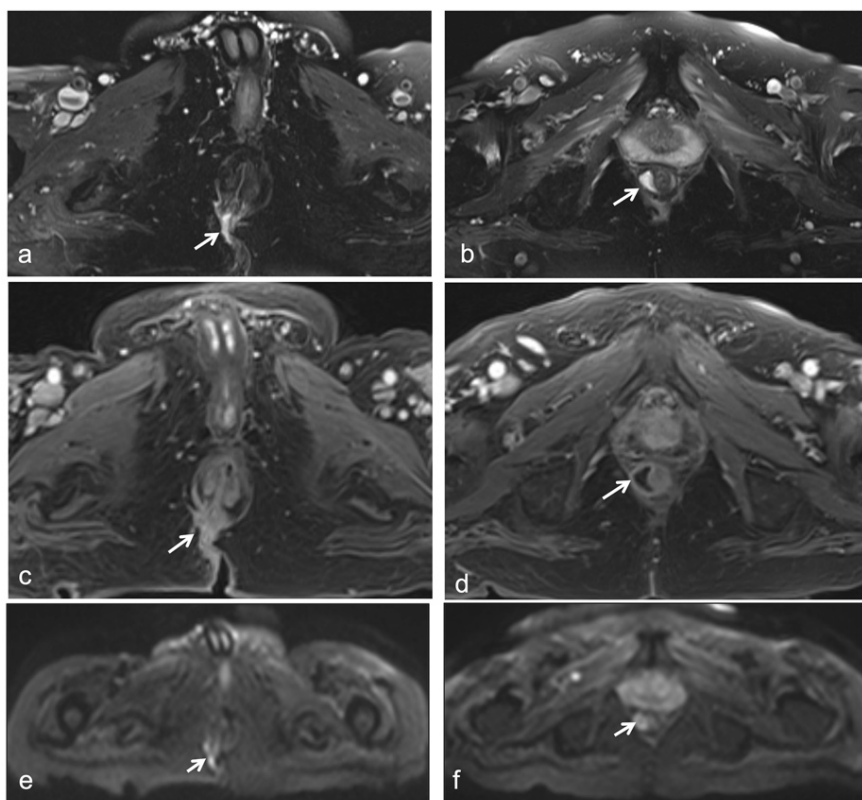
1,5T perianal MR imaging with i.v. contrast media injection of the same patient. a and b; axial T2W FS images a. hyperintense transphincteric fistula tract at 6 o'clock position (arrow), b. accompanying perianal abscess in the intersphincteric space (arrow). c and d; axial postcontrast T1W FS images c. hyperintense transphincteric fistula tract (arrow) with lateral minimal irregular extensions, d. intersphinctericperianal abscess (arrow) with rim enhancement, e and f; hyperintense fistula and abscess on DWI.
